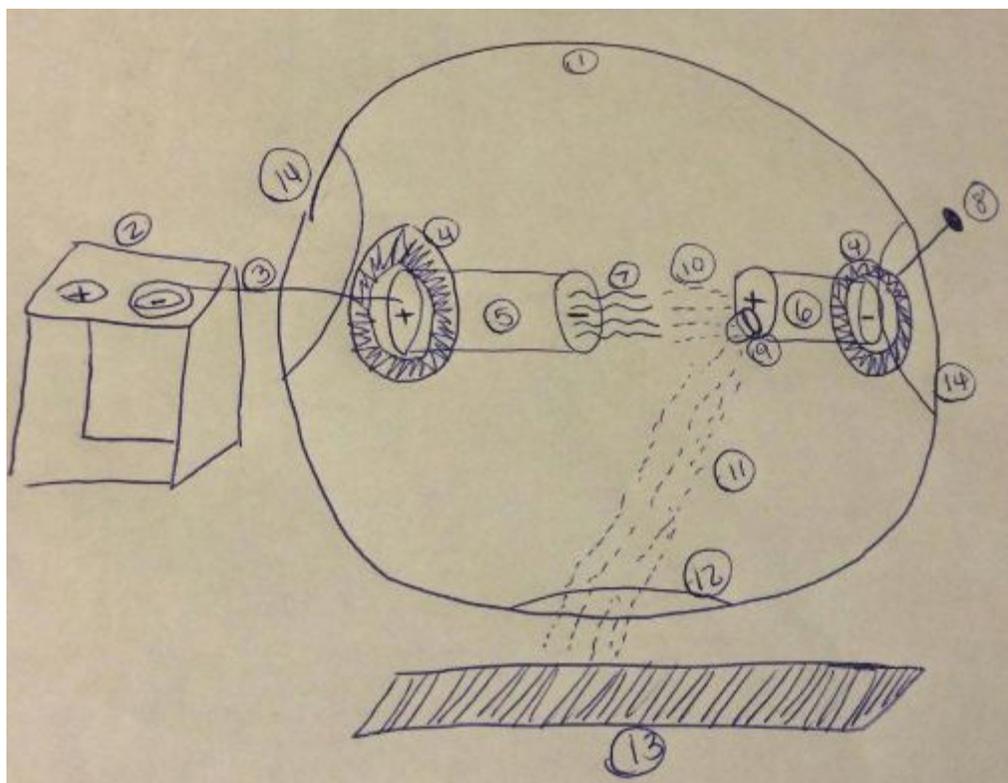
X-Ray Tube for Children's Medical Device Kit
